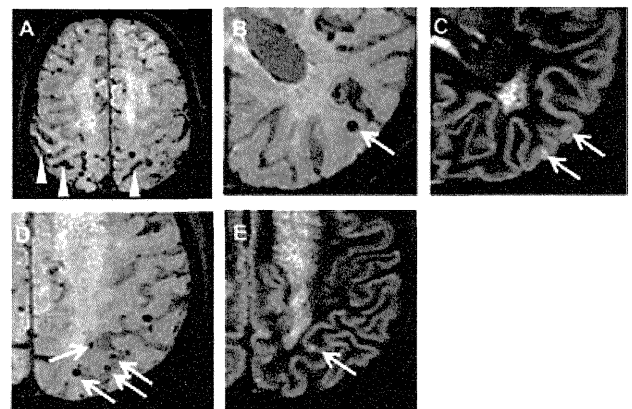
Head MR images in a 78-year-old man with VaD (Patient 4). SWI demonstrates multiple lobar CMBs predominantly in the parietooccipital lobes as well as focal superficial siderosis (arrowheads) adjacent to the CMBs in the bilateral parietal lobes (A). DIR image shows small intracortical high signal lesions (arrows in C, E) close to lobar CMBs (arrows in B, D).
